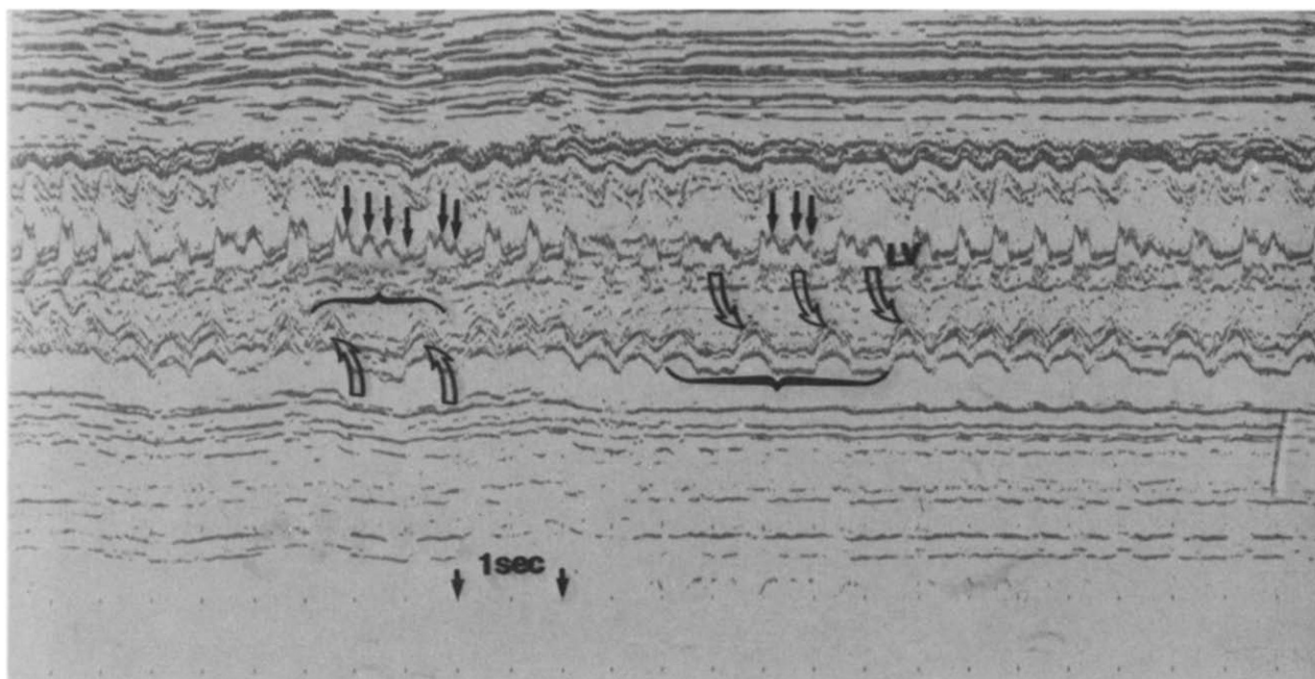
M-mode echocardiogram in a 32 week old fetus with supraventricular tachyarrhythmia. Motion of left ventricular (LV) posterior wall (curved arrows) suggests an irregular ventricular response caused by a variable atrioventricular block. Rapid undulations reflecting atrial flutter rate of 480 beats/min are reflected on the atrioventricular valves (vertical arrows). This echocardiogram was recorded after administration of digoxin and verapamil to the mother of the fetus.
